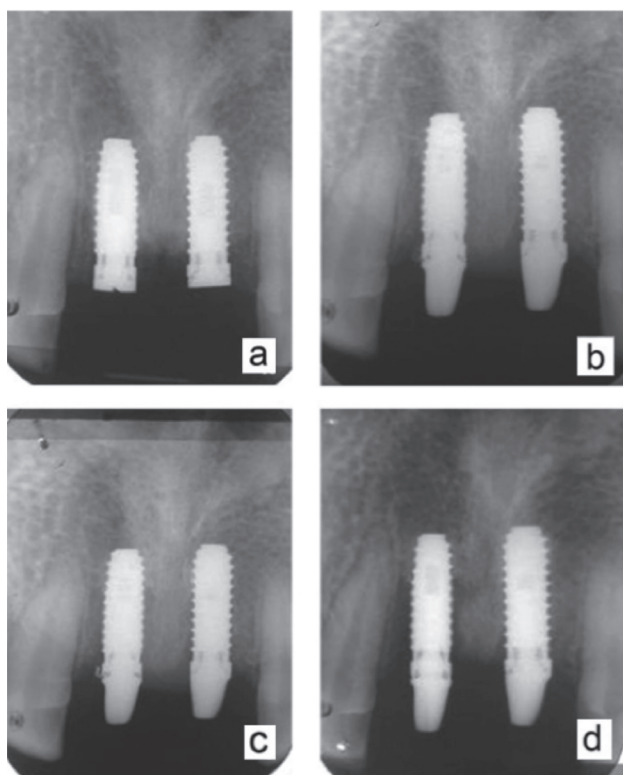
Periapical X-ray of control (left) and B-G coated (right) implants at immediate postoperative period (a), 5 weeks (b), 6 months (c) and 12 months after permanent prosthetic attachment (d)⁶⁴.
